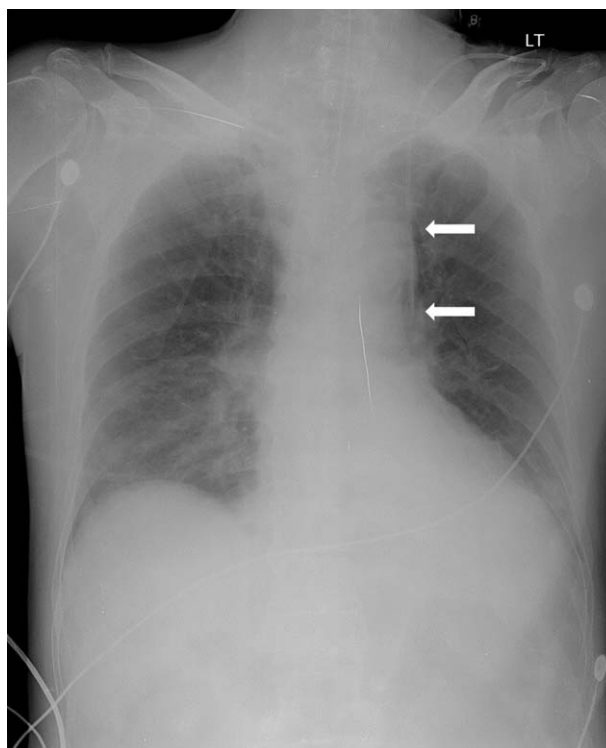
Postoperative chest radiograph revealed the central venous catheter (white arrows) passing along the border of the left heart and the tip in an unusual position.
